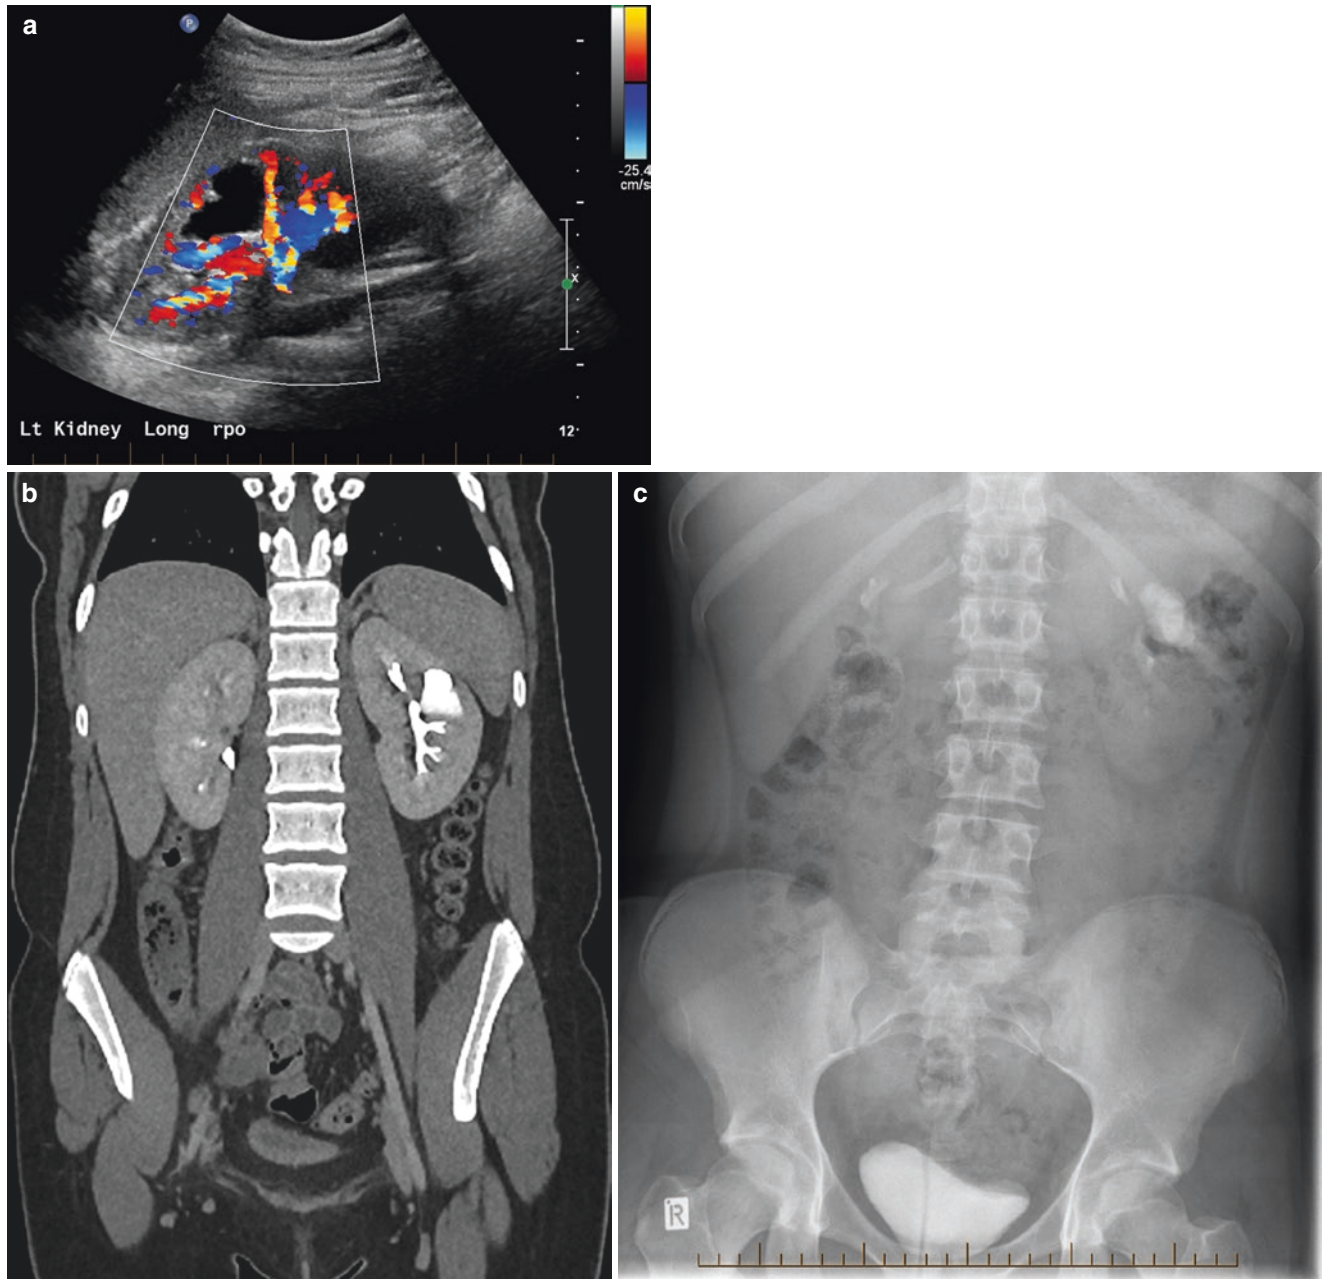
(a) Longitudinal ultrasound image of a calyceal diverticulum. While the differential diagnosis of this anechoic structure would include a cyst, the morphology is suggestive of a dilated calyx. (b) Coronal contrast enhanced CT, urographic phase, demonstrating an isolated dilated calyx in the upper pole of the left kidney. Contrast within
